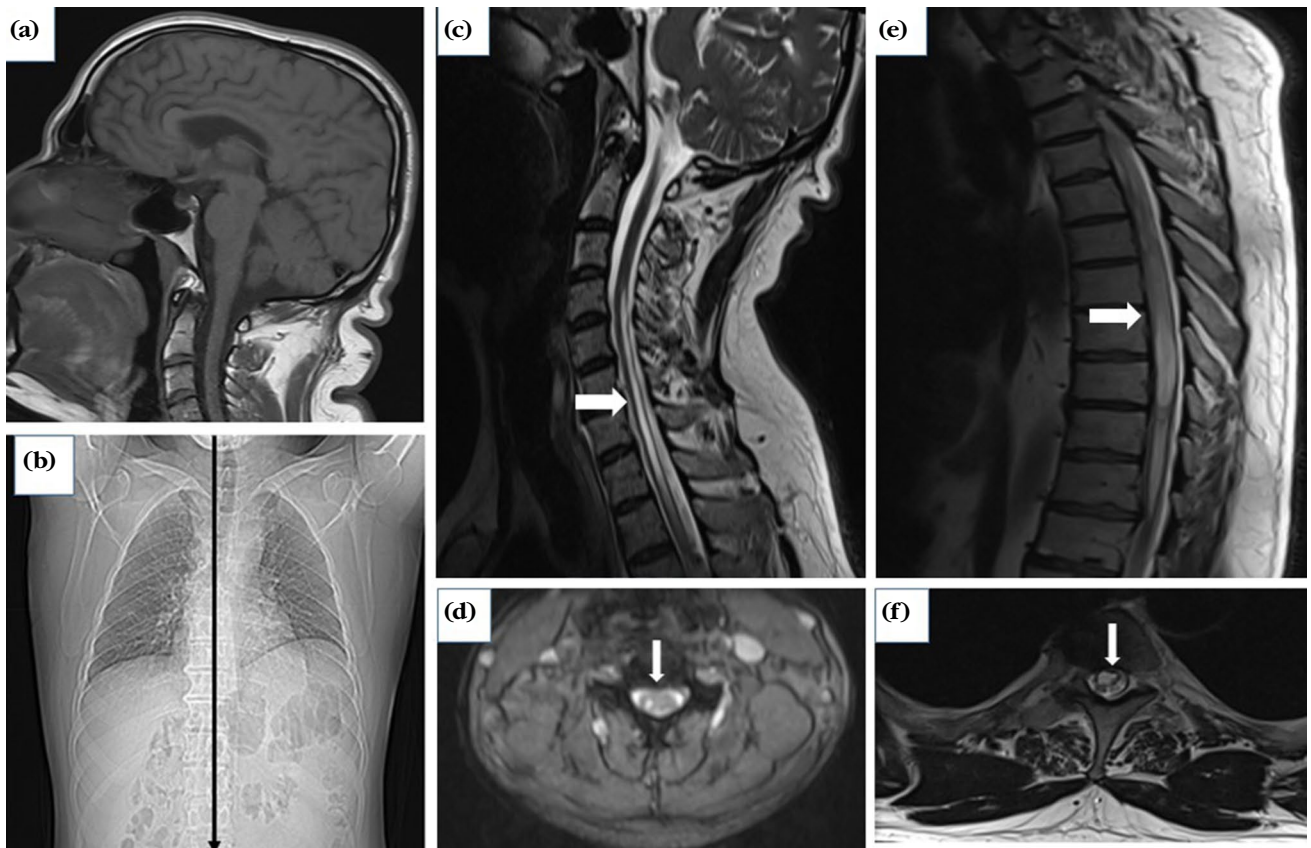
Images of Case 1. (a) Midsagittal T1-weighted magnetic resonance imaging of the craniocervical junction. (b) Posteroanterior radiograph of the thorax showing scoliosis. (c, d) Midsagittal and axial T2-weighted magnetic resonance imaging of the cervical spinal cord showing a syrinx cavity extending from C4 to T1 with a diameter of 3 mm at its widest point; (e, f) Sagittal and axial T2-weighted magnetic resonance imaging of the thoracic spinal cord with a syrinx cavity extending from T2 to T11 with a diameter of 8 mm at the widest point.
